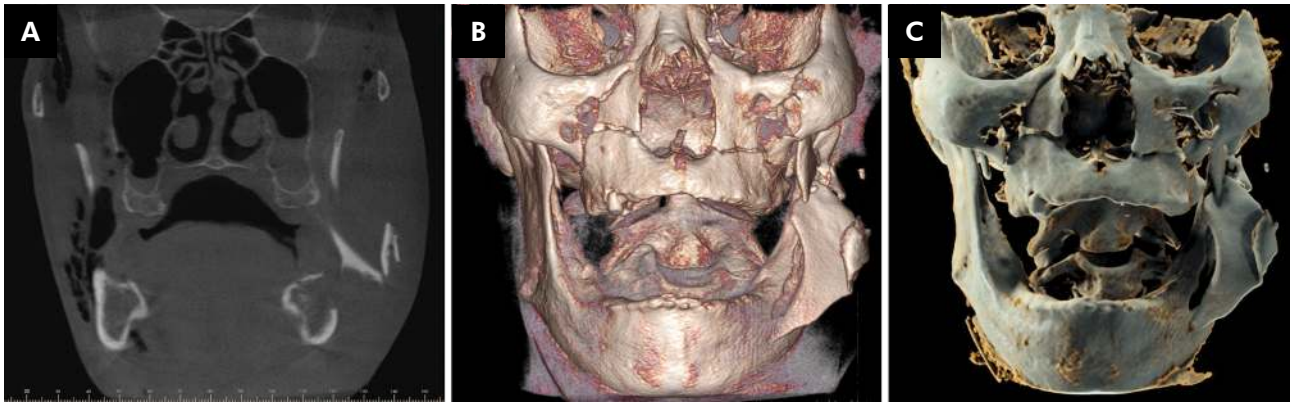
Case 5 (A-C). A 58-year-old man was referred to a private oral and maxillofacial radiology clinic (CROIF, Cuiabá, Brazil) for imaging studies to assess facial trauma after a serious motor-vehicle accident. Clinical examination revealed facial trauma and trismus. CBCT scan showed multiple facial fractures (A-C). The diagnosis was multiple facial fractures involving the mandible, maxilla, nasal fossa, floor of the orbit and zygomatic arch. The e-Vol DX software and its advanced 3D cinematic rendering tool (C) provided elements for a better analysis of fragment shapes and location and supported the decision of whether fragments should be kept or removed, as well as the planning of bone fragment repositioning during surgical facial reconstruction.
